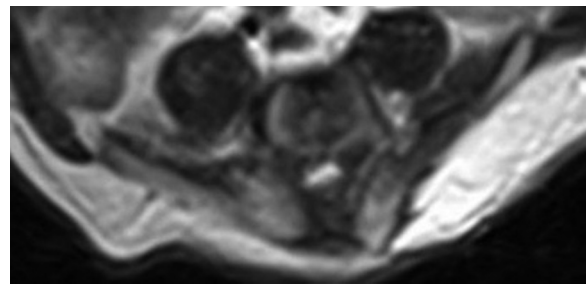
Transverse axial T2-weighted MRI of the lower neonatal spine shows abnormal approximation of iliac bones and absence of the sacrum. (transverse axial TSE T2; TR, 4,900; TE, 4)
